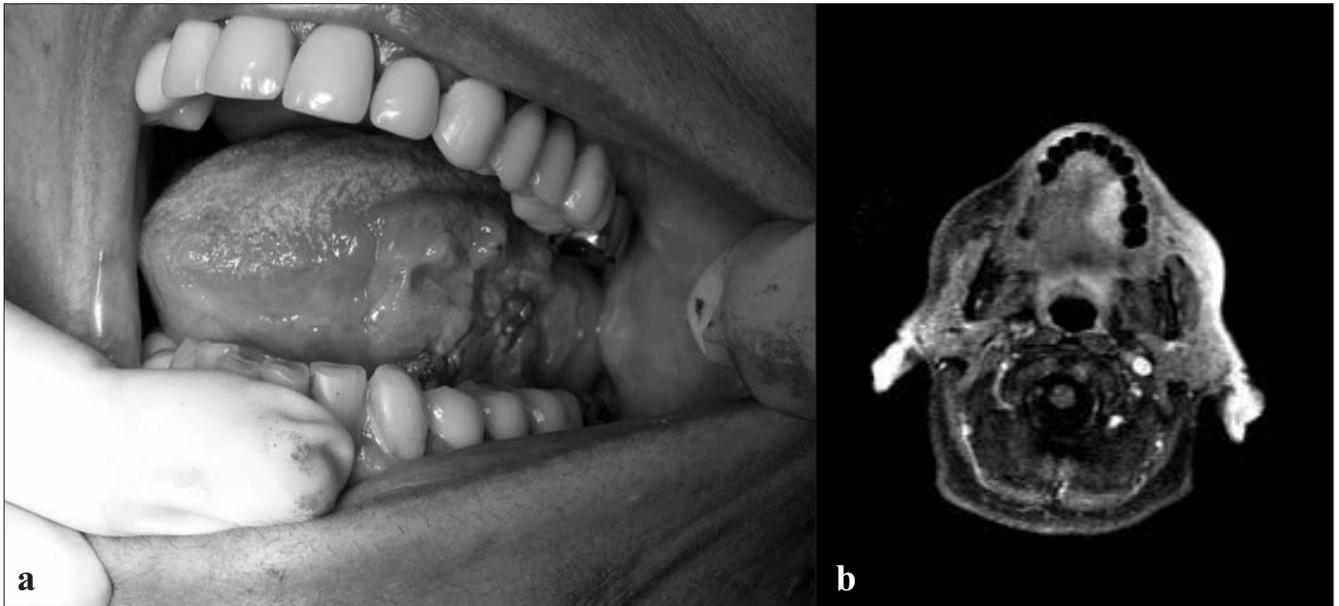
Left tongue tumor. Clinical examination shows a lesion in the left tongue (a). MRI with fat suppressed sequences after Gd-DTPA infusion (b) shows an area with strong enhancement classified as T2 confirmed by pathological data.
